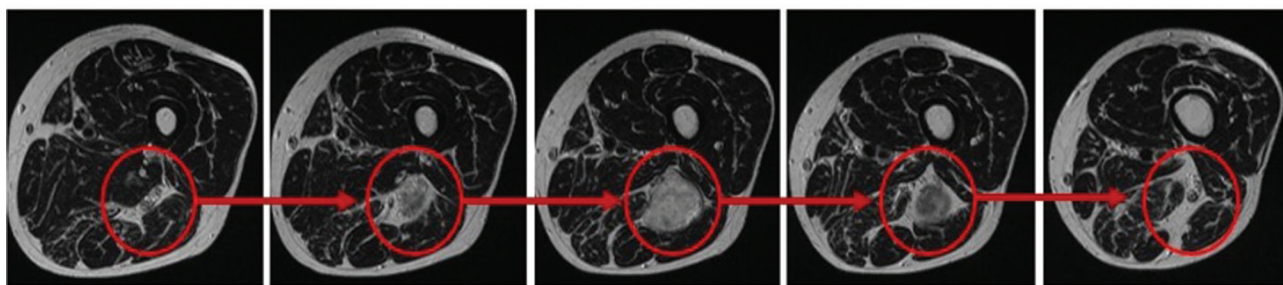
A series of transverse axial MRI T1-weighted scans (from proximal on the left to distal on the right) shows a sciatic nerve in the middle third of a thigh with an intraneuronal schwannoma (particularly visible in the middle scan).
